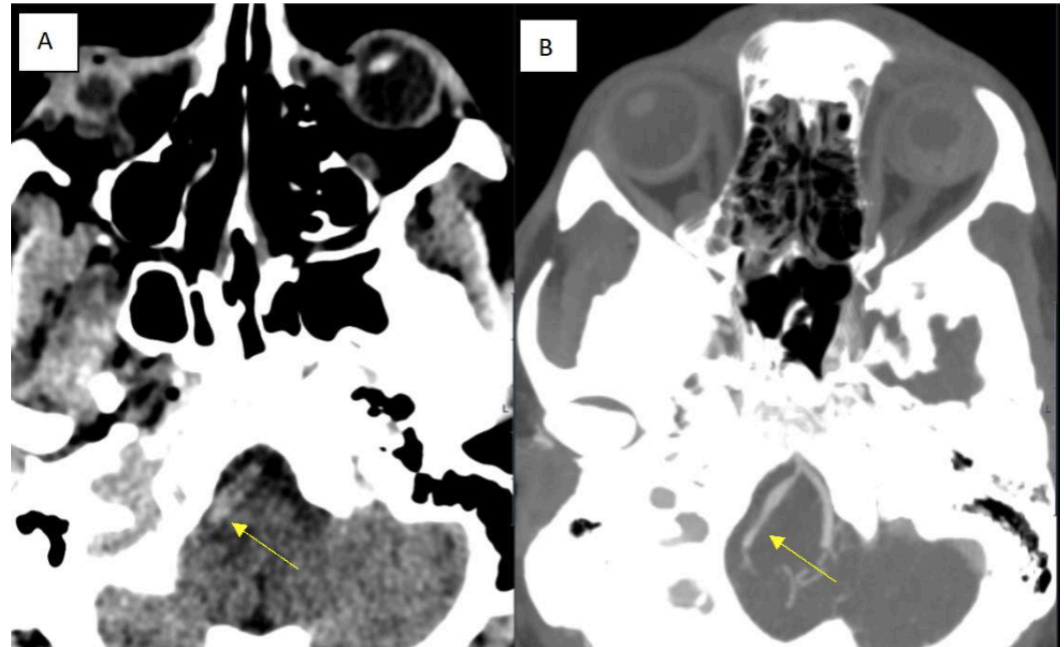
Unenhanced computed tomography (CT) head and CT angiogram (CTA) imaging at initial presentation. (A) CT head showing focal hyperdensity in the V4 segment of the right vertebral artery (yellow arrow). (B) CTA showing corresponding irregularity (yellow arrow) suggestive of dissection.
